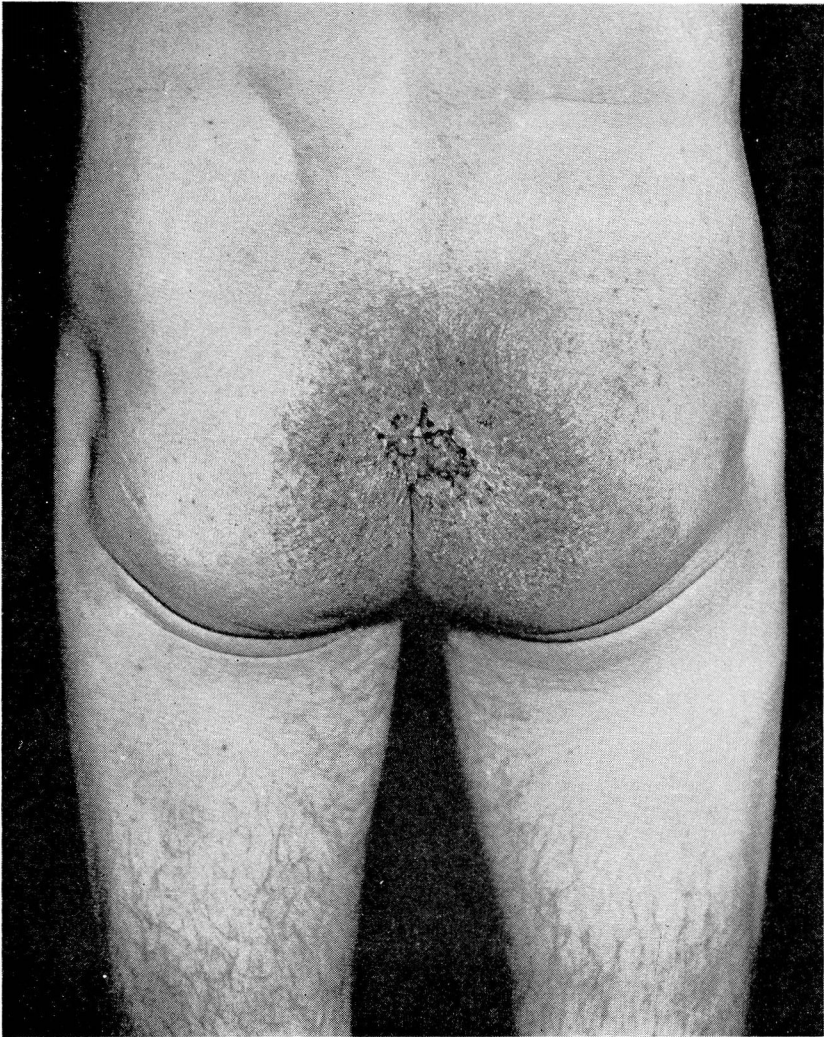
Radiodermatitis with ulceration following roentgen therapy for pruritus ani.
